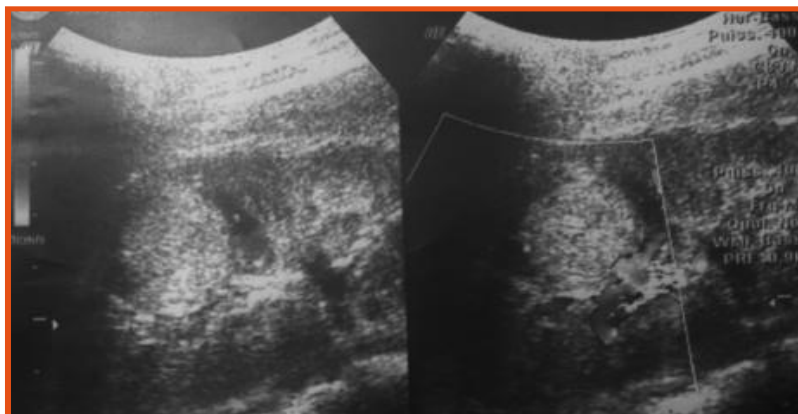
Longitudinal sonogram of the right kidney: hyperechoic, medio-renal mass showing slight vascularization on doppler color US
